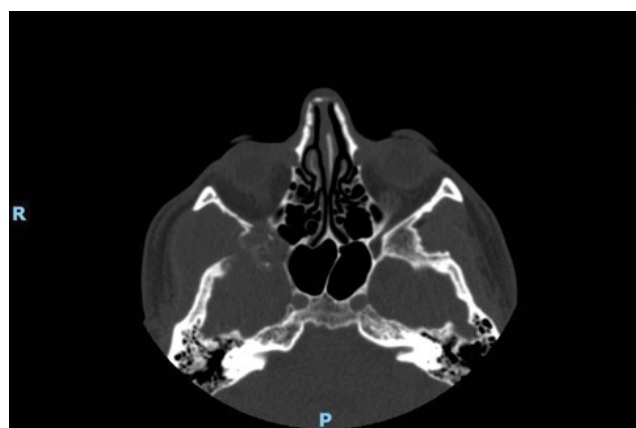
CT scan, pre-operative axial image.
